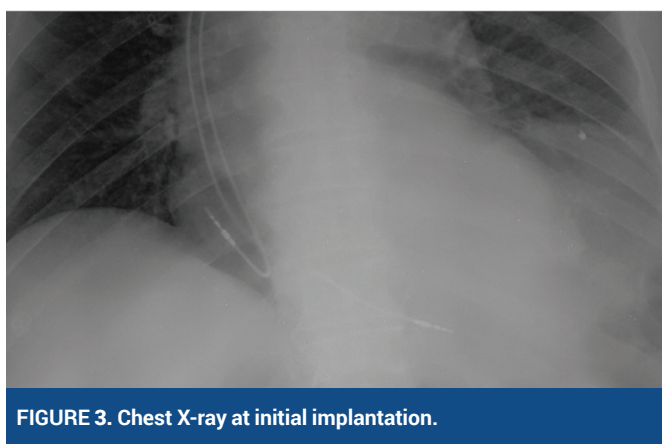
Chest X-ray at initial implantation.
